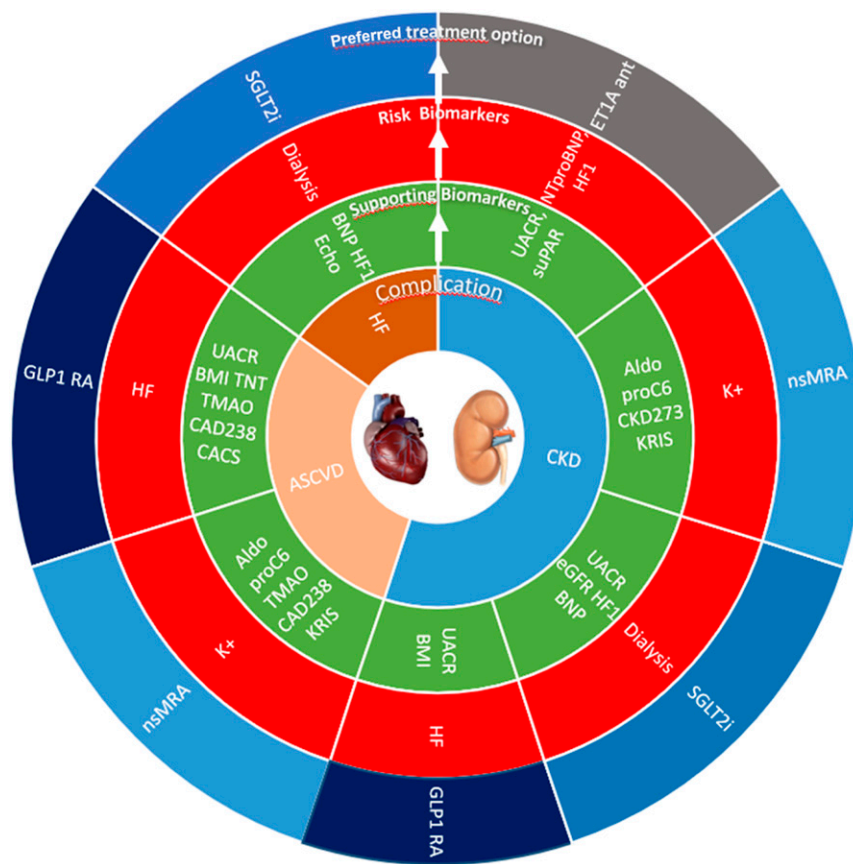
Biomarker-guided treatment selection. A proposal for how biomarkers could guide selection of treatment among recently tested options with a precision medicine approach in diabetic kidney and heart disease (“Complication” in inner circle). Using available “Supporting Biomarkers” (green circle) reflecting underlying pathology and “Risk Biomarkers” (red circle) to select optimal treatment (outer circle) in patients with type 2 diabetes. Thus, as an example in CKD: elevated urinary albumin-to-creatinine ratio (UACR) or fluid retention (brain natriuretic peptide [BNP]) would suggest an SGLT2 inhibitor (SGLT2i), whereas markers of inflammation and fibrosis would suggest nonsteroidal MRA (nsMRA) (currently not available), and suPAR would suggest endothelin receptor 1A antagonist (ET1Aant) (currently not available) unless there are signs of fluid retention (elevated NTproBNP). Aldo, aldosterone; ASCVD, atherosclerotic CVD; HF, heart failure; CKD, chronic kidney disease; Echo, echocardiography; CACS, coronary artery calcium score; K+, potassium; U-CKD273, urinary proteomic marker of chronic kidney disease; u-CAD238, urinary proteomic marker of coronary heart disease; HF1, urinary proteomic marker of heart failure; proC6, serum PRO-C6 (marker of fibrosis); TNT, troponin T; suPAR, soluble urokinase plasminogen activator receptor.
